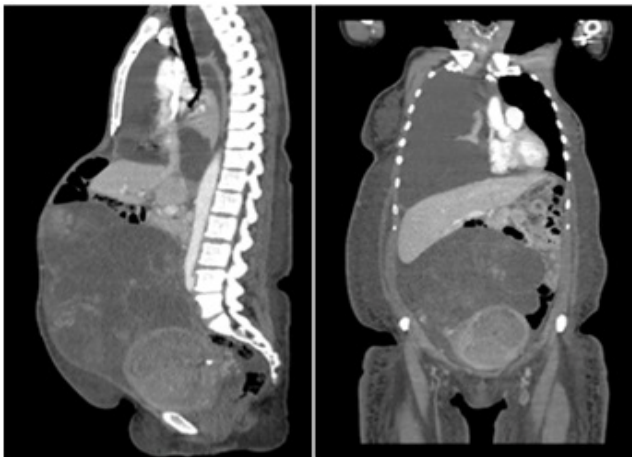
Coronal and sagittal reconstruction of phase-contrast Computer Tomography (CT), in which right pulmonary collapse can be observed at the expense of massive pleural effusion with displacement of the cardiome-diastinum to the left. At the level of abdominal cavity and pelvis, occupation of the heterogenous neoformation dependent on right ovary, as well as implants in left mesenterinum due to carcinomatosis and uterus with increase in dimensions due to intramural myomatosis. Edema of soft tissues.
